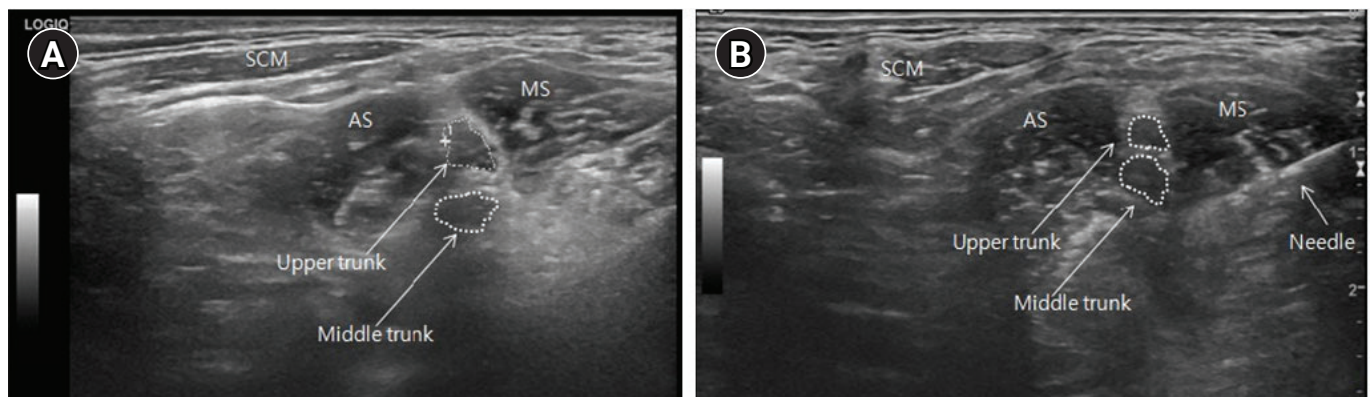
Ultrasound-guided injection to left brachial plexus at the trunk level with 20mg triamcinolone acetone and lidocaine 25mg. A) Before the injection; B) During injection. SCM: sternocleidomastoid, AS: anterior scalene, MS: middle scalene.
